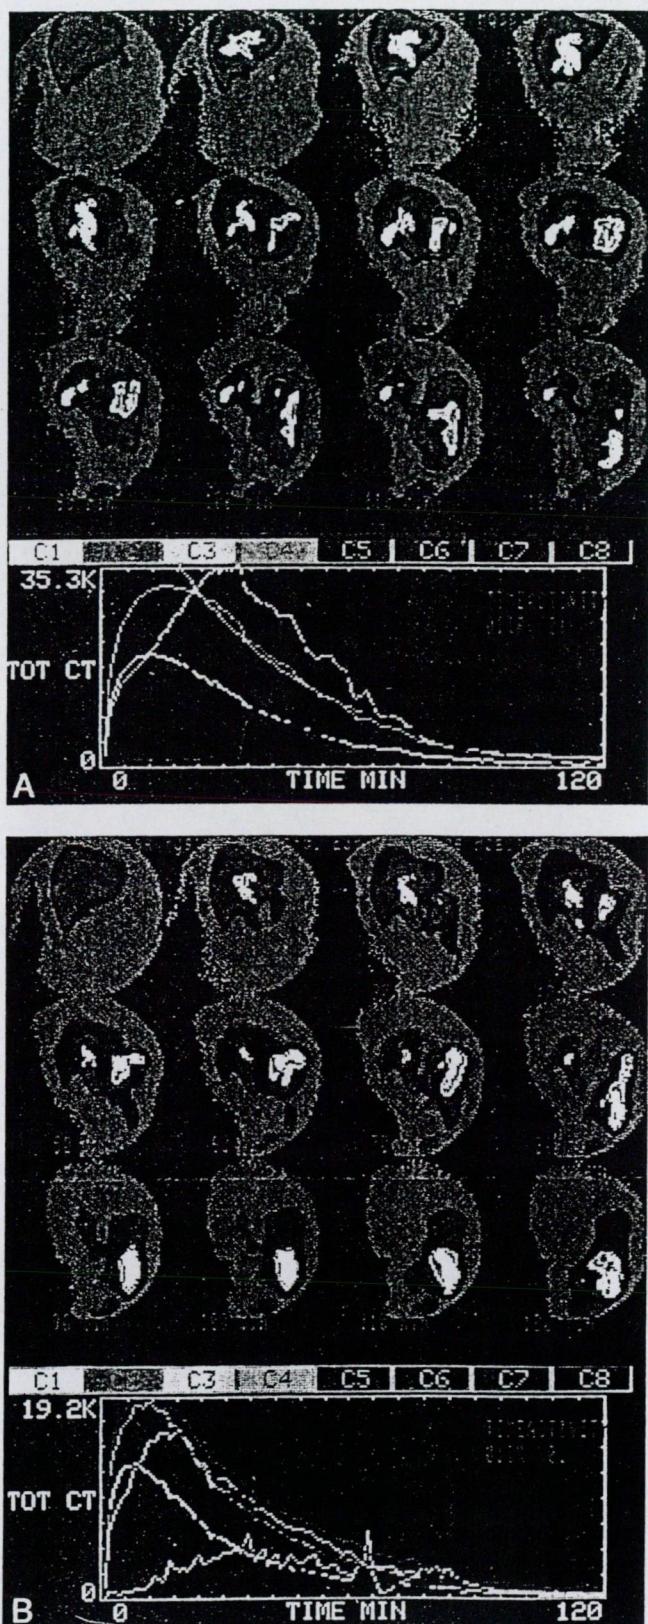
Representative hepatobiliary scintigram of a patient before (A) and after (B) cholecystectomy. Note the obvious acceleration of the isotope emptying after operation.
